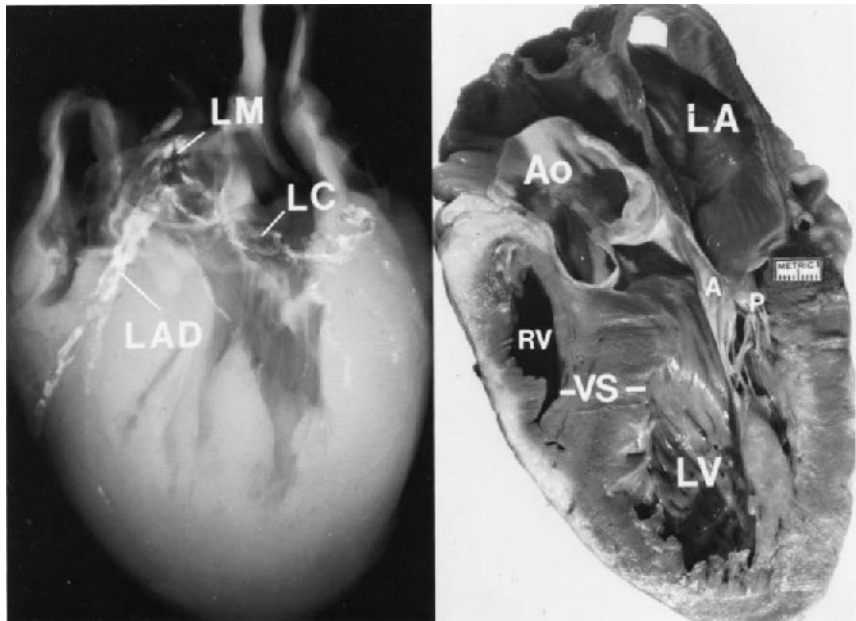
This 90-year-old woman (SH #A82-1) had no symptoms of cardiac dysfunction and died from a ruptured fusiform abdominal aortic aneurysm. Left: postmortem radiogram of the entire heart showing calcific deposits in the left anterior descending (LAD), left circumflex (LC), and left main (LM) coronary arteries. Right: view of heart cut in an anteroposterior fashion (M-mode or long-axis two-dimensional echocardiographic view) showing a dilated left atrium (LA) and left ventricle (LV). A and P = anterior and posterior mitral valve leaflets; Ao = aorta; RV = right ventricle; VS = ventricular septum.
